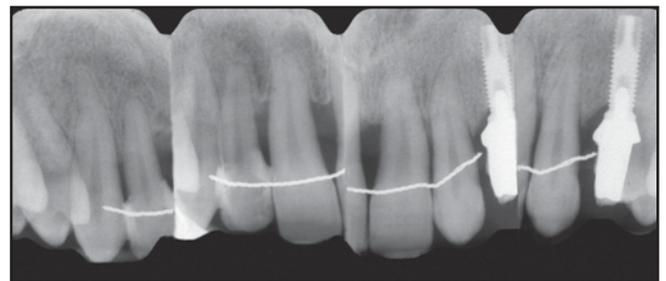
Radiograph at 3 months after MTDLD treatment.*
